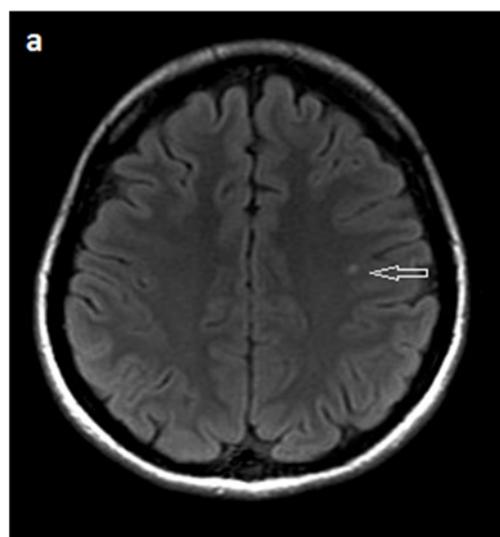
Brain magnetic resonance images (MRI) presentation:
